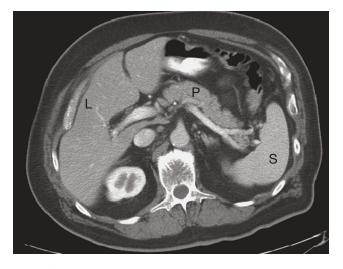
Normal-Enhanced Computed Tomography of the Pancreas. Note that the pancreas (P) has a uniform enhancement intermediate between that of the liver (L) and spleen (S).
